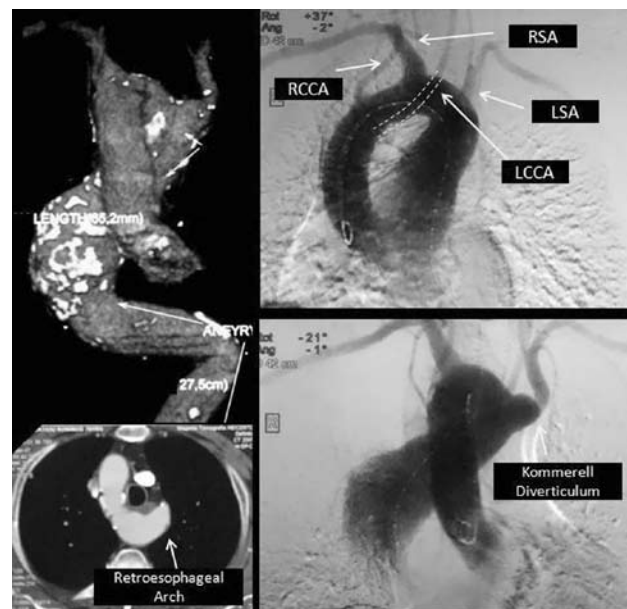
CT angiography and digital subtraction angiography indicating a right sided DTAA associated to a right aortic arch (RAA) with a retroesophageal segment and an aberrant left subclavian artery arising from a Kommerell's diverticulum.
